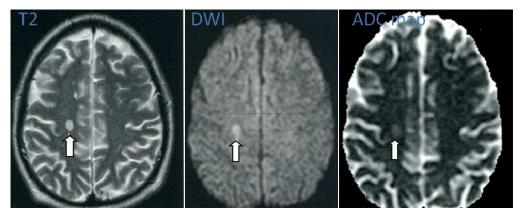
Hyperintense lesion at the right semioval center with increased signal intensity on DWI and increased signal intensity on ADC map, due to vasogenic edema.
